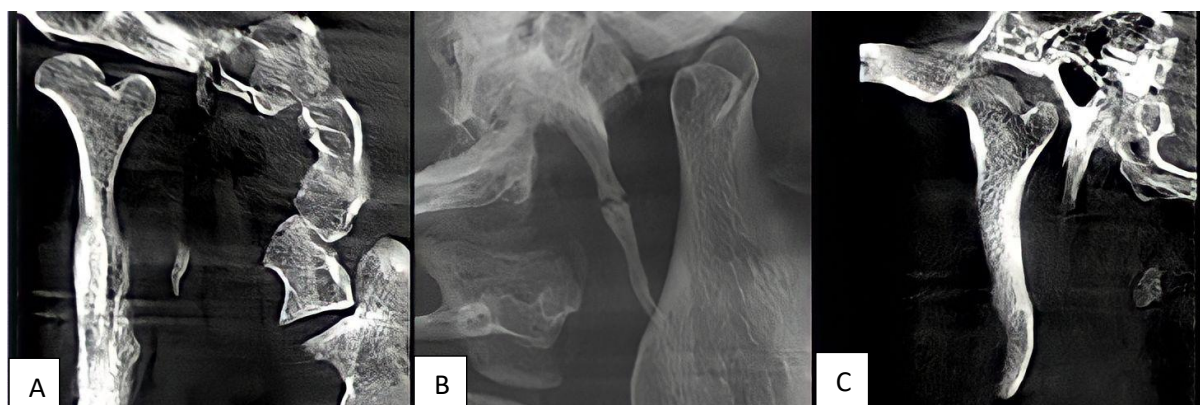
CBCT images of the right temporomandibular joint. Coronal section shows the condylar morphology bifurcated by a sharp depression resulting in a "double" head with asymmetrical portions (A). In the panoramic view, open mouth position, note the mid-lateral orientation (B). With the mouth closed, it signals the right mandibular condyle centered in the joint cavity (C).
